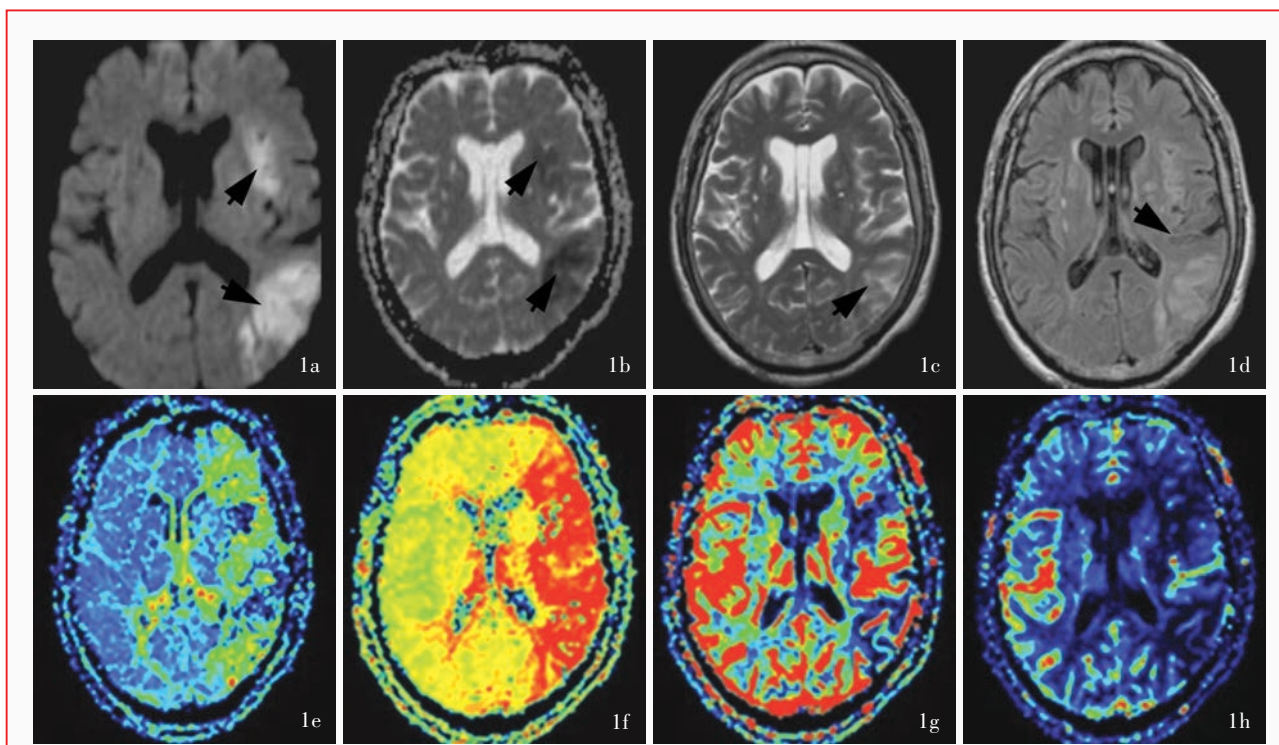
男性患者,56岁。主因突发言语不清、右侧肢体活动不利4h就诊。临床诊断:缺血性卒中。头部MRI检查所见 1a 横断面扩散加权成像(DWI)显示左侧额颞岛叶交界区、左侧颞枕叶交界区斑片状异常高信号(箭头所示),提示超急性期缺血灶 1b 横断面表现扩散系数(ADC)图显示上述区域异常低信号(箭头所示) 1c 横断面T<sub>2</sub>WI显示左侧侧裂、颞枕叶交界区脑沟变浅(箭头所示) 1d 横断面FLAIR成像显示左侧侧裂内线样慢血流征(箭头所示) 1e 左侧大脑中动脉供血区及后分水岭区血流平均通过时间(MTT)明显延长(绿色区域所示) 1f 左侧大脑中动脉供血区及后分水岭区血流达峰时间(TTP)明显延长(红色区域所示) 1g 脑血容量(CBV)图显示左侧岛叶、左侧颞枕叶交界区异常低灌注(蓝黑色区域所示) 1h 脑血流量(CBF)图显示左侧大脑中动脉供血区域信号明显降低(黑色区域所示),异常低灌注区面积大于DWI,提示存在缺血半暗带
